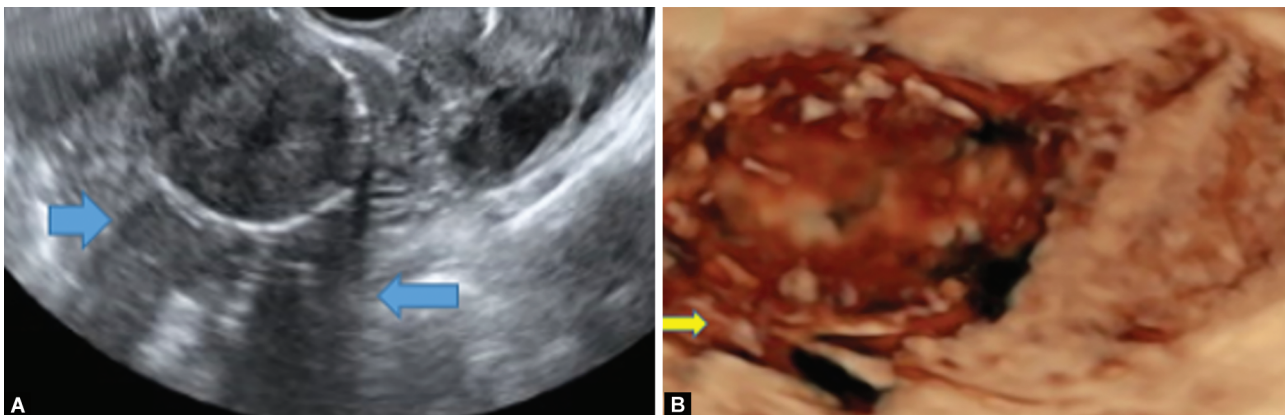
3D ultrasonography: asymmetry of uterine walls with a large fibroid on the posterior wall (yellow arrows)
